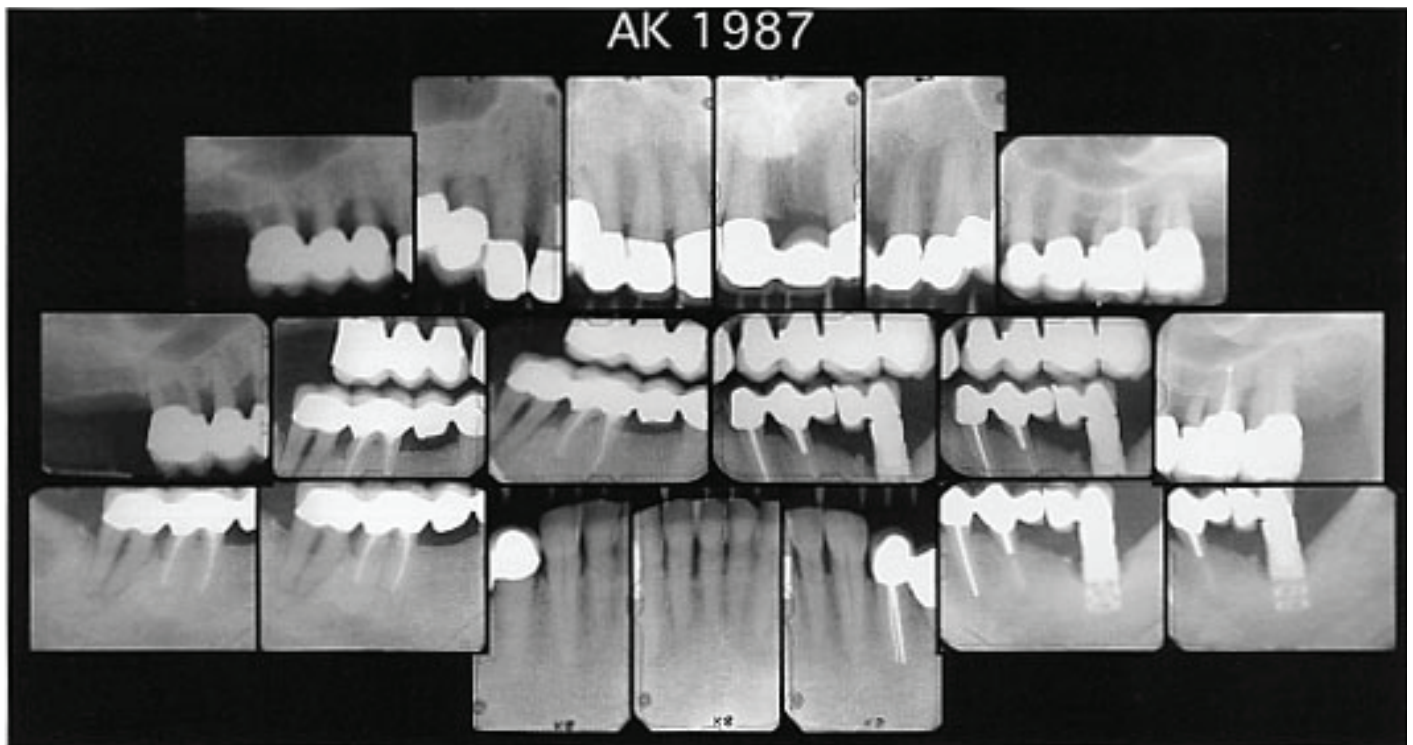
Full-mouth X-rays, 1987.
